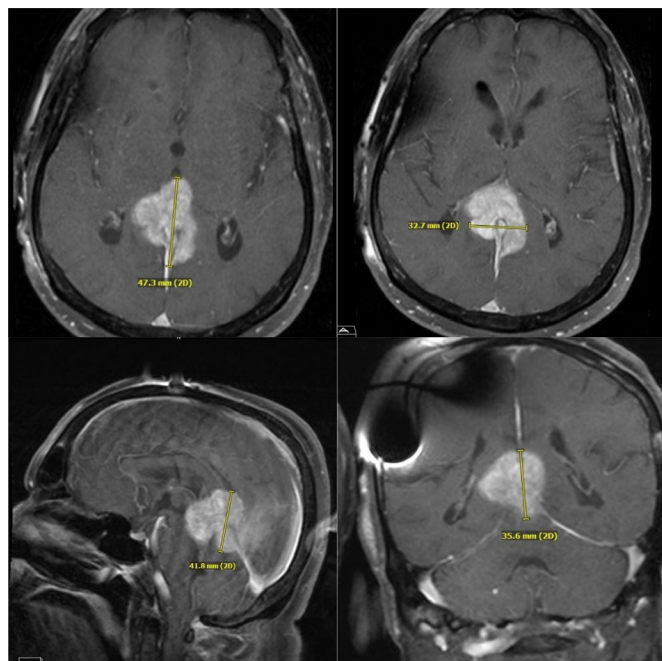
Transverse (top left and top right), sagittal (bottom left) and coronal (bottom right) T2-weighted brain MRI images from referring hospital with measurements overlaid on the brain tumour. 2D, two dimensional.
